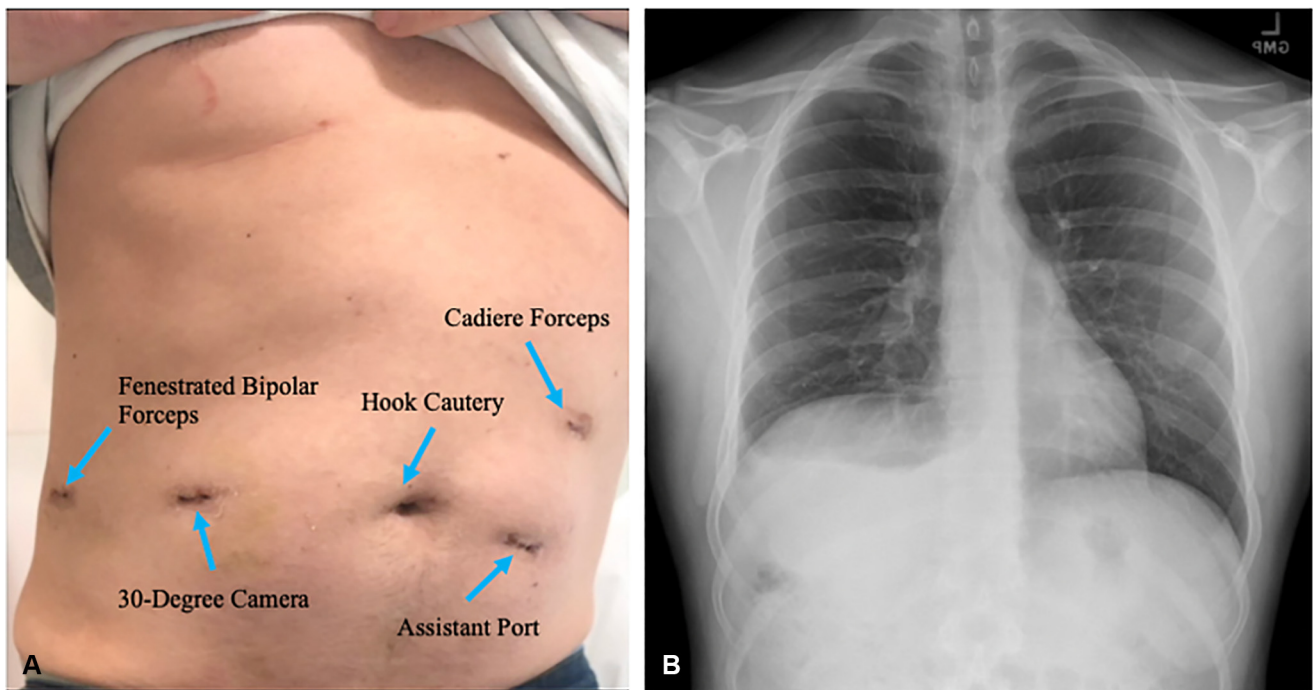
(A) Postoperative image highlighting the abdominal incisions made for port placement and instruments used in each port (B) Postoperative radiograph demonstrates resolution of the hernia.
